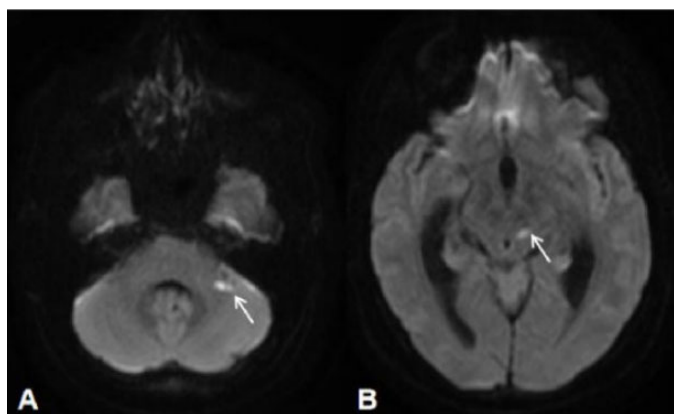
Brain diffusion-weighted MRI images, axial view: (A) left middle cerebellar peduncle acute ischemic lesion. (B) Mesencephalon acute ischemic lesion consistent with infarctions due to small perforating vessels occlusion (white arrows).
